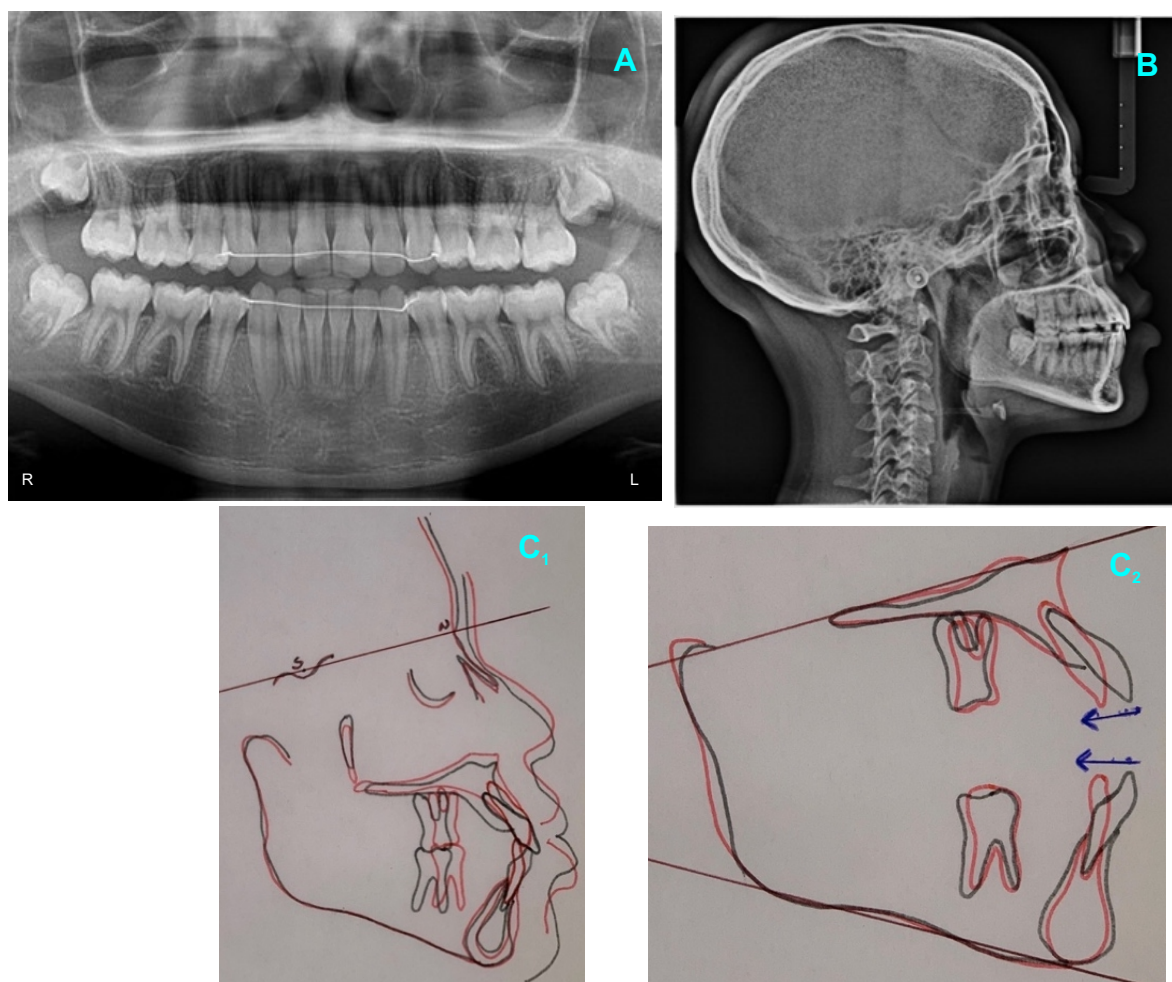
A - Post-Treatment Panoramic Radiograph; B - Cephalogram; and C- Superimposition
